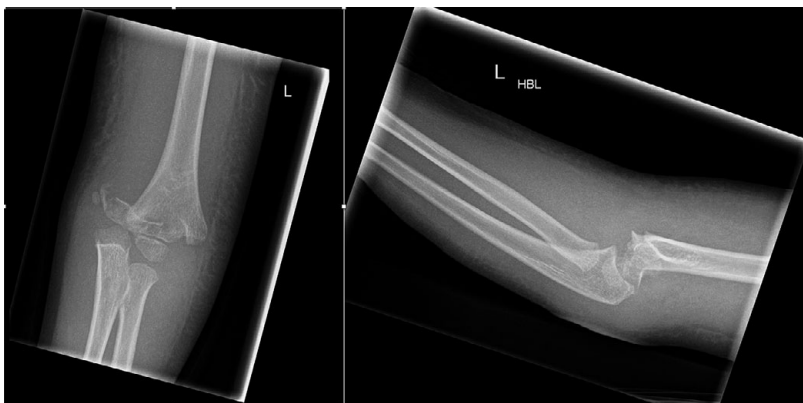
Anteroposterior (AP) and lateral radiographs elbow
